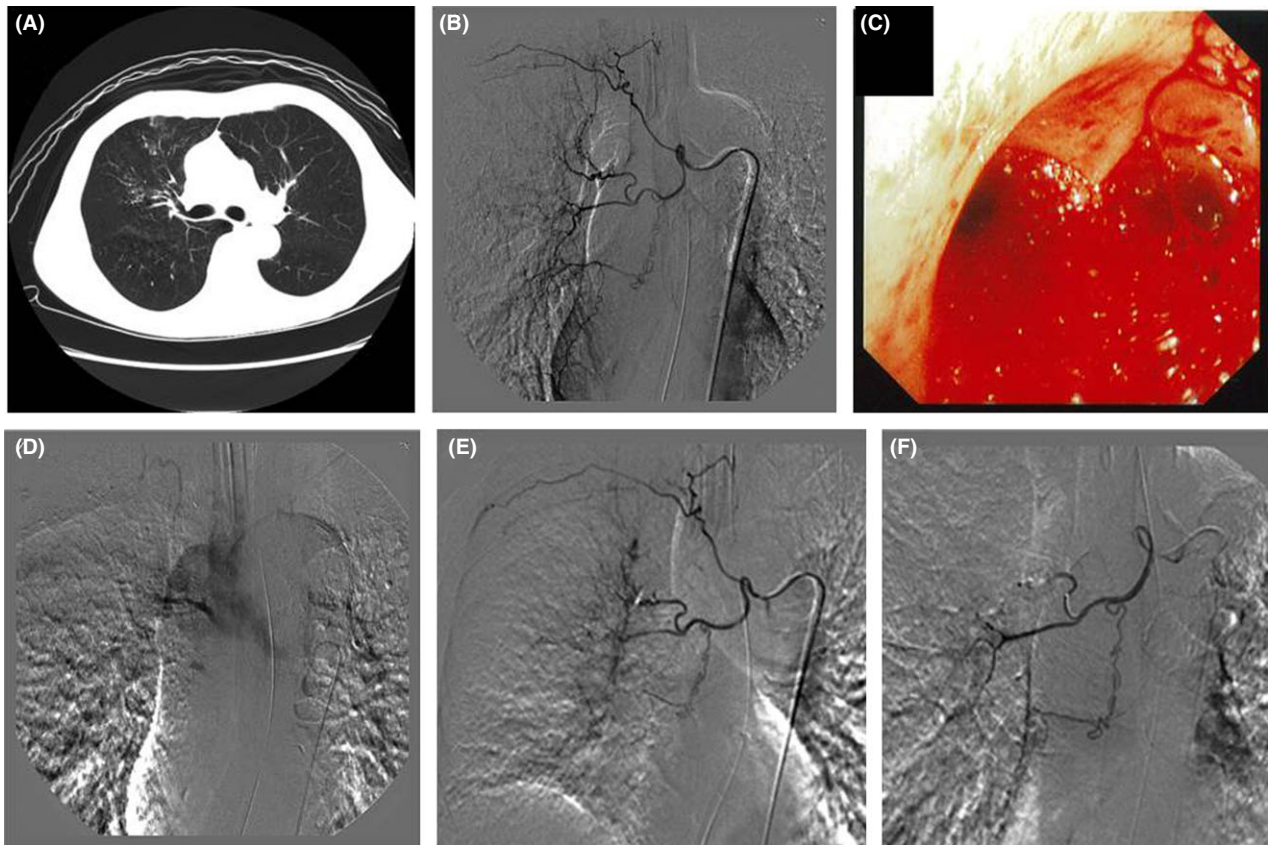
A, Contrast-enhanced computed tomography findings of a 72-year-old man revealed only ground-glass opacity that was dominant in the right lung field. No vascular abnormality nor extravascular leakage was noted. B, Vascular dilatation >2 mm was found on the central side; the vascular abnormality in the periphery showed diffuse spreading. C, D, While securing the safety of the airway, blood clots were aspirated with a bronchoscope during angiography, which resulted in confirmation of massive foamy hemoptysis. Intercostal angiography at that time also revealed extravascular leakage from the lobar bronchus to right main bronchus. E, Angiographic findings after airway suctioning showed visible changes in the vascular abnormality in the periphery of the right bronchial artery. Thus, the culprit vessel causing massive hemoptysis was identified by removing blood clots. F, Embolization of the right bronchial artery was carried out.
